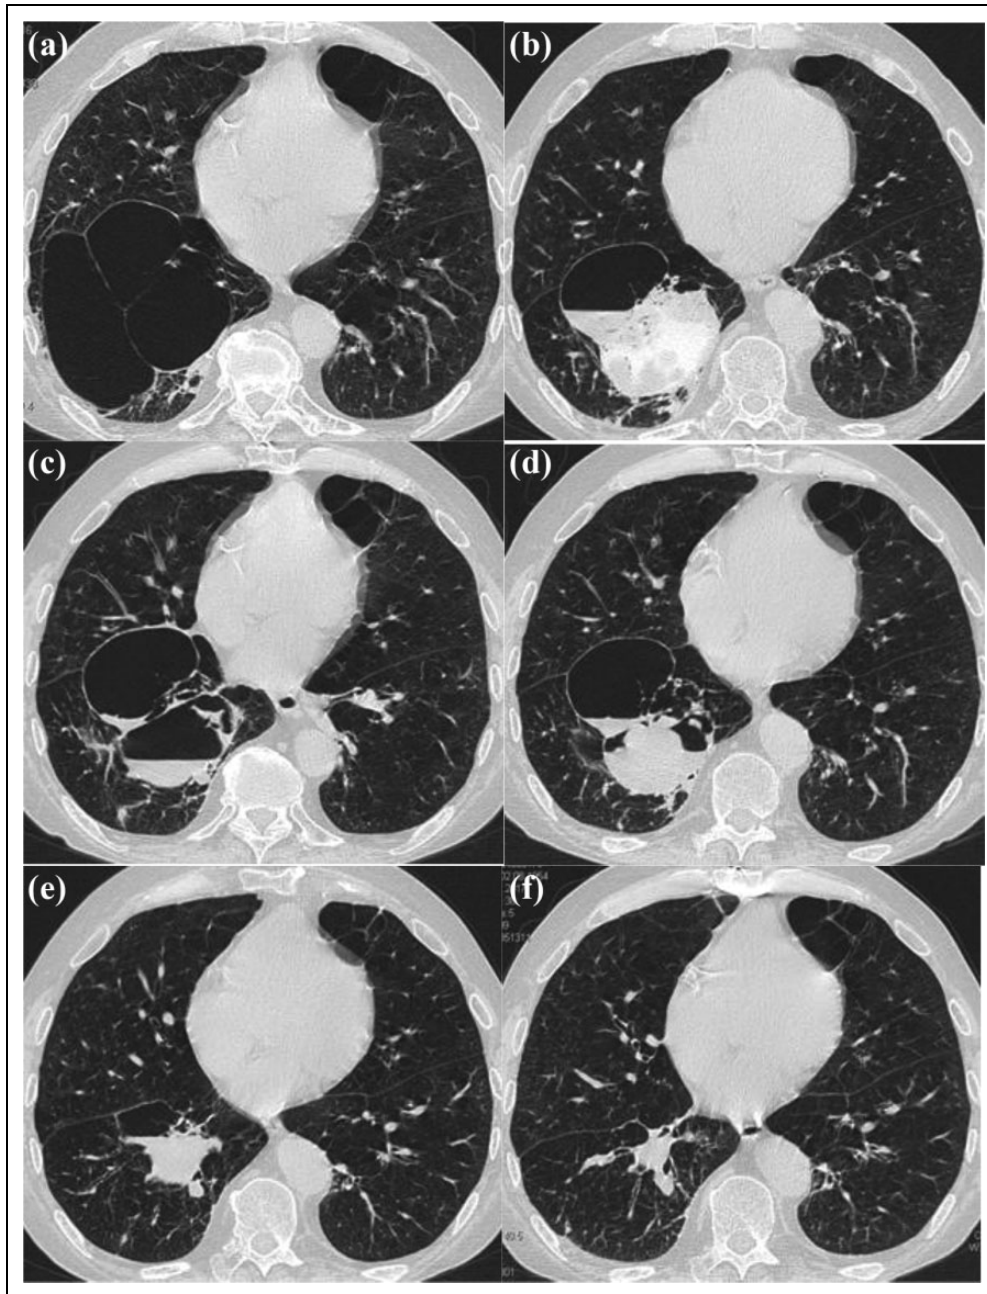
Thoracic CT on the same level pre-interventional (a) and 2 h (b), 7 days (c), 17 days (d), 38 days (e), and 126 days (f) after intervention, demonstrating the shrinkage of the three bullae ($11 \times 12 \text{ cm}^2$).
